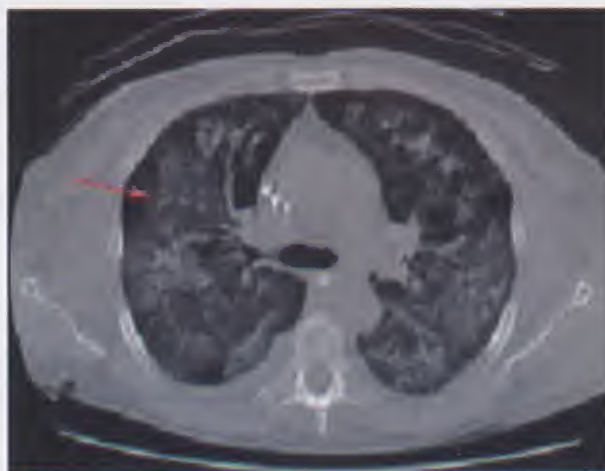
CT scan in a patient with ARDS showing ground glass appearance (arrow) and alveolar infiltrations
